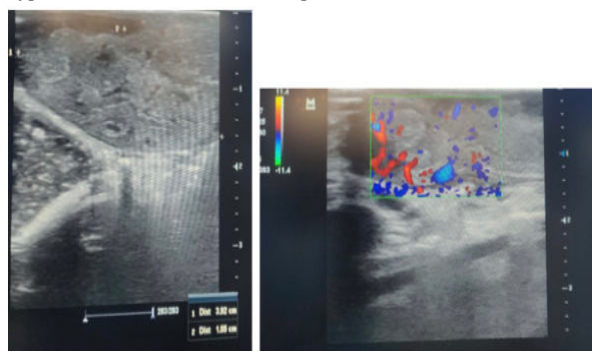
intraop ultrasound showing suspicious hyper vascular lesion in head of pancreas.
